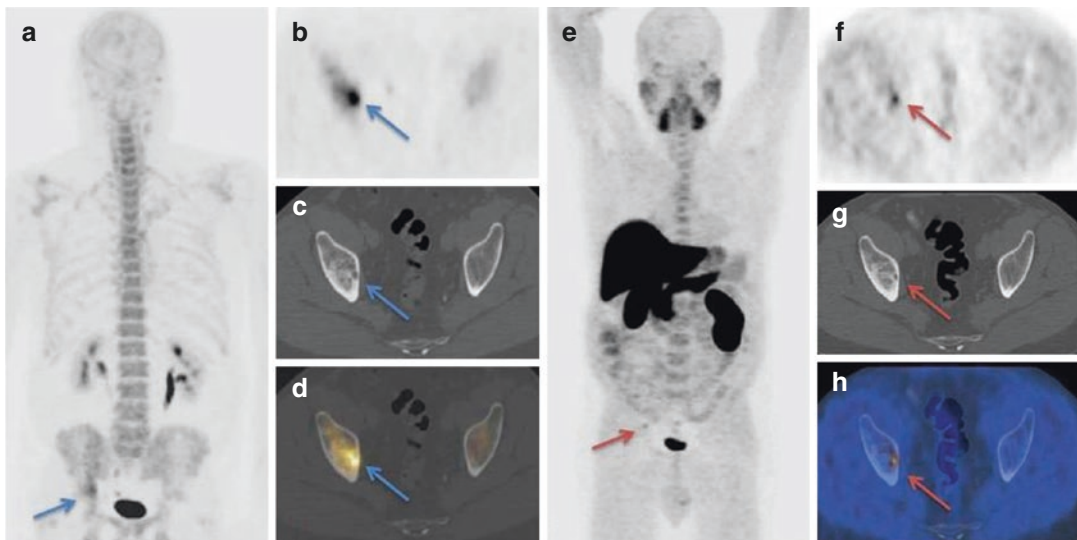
A patient with early biochemical relapse of prostate cancer (PSA 0.8 ng/mL) after radical prostatectomy was examined by means of ^{18}F -NaF PET/CT and ^{18}F -choline PET/CT. The whole body, 3D, ^{18}F -NaF PET maximum intensity projection (a) and axial PET view (b) show a single area of focal tracer uptake in the right ischium, in association with geodic lesion, evident in corresponding CT (c) and PET/CT (d) views. The whole
